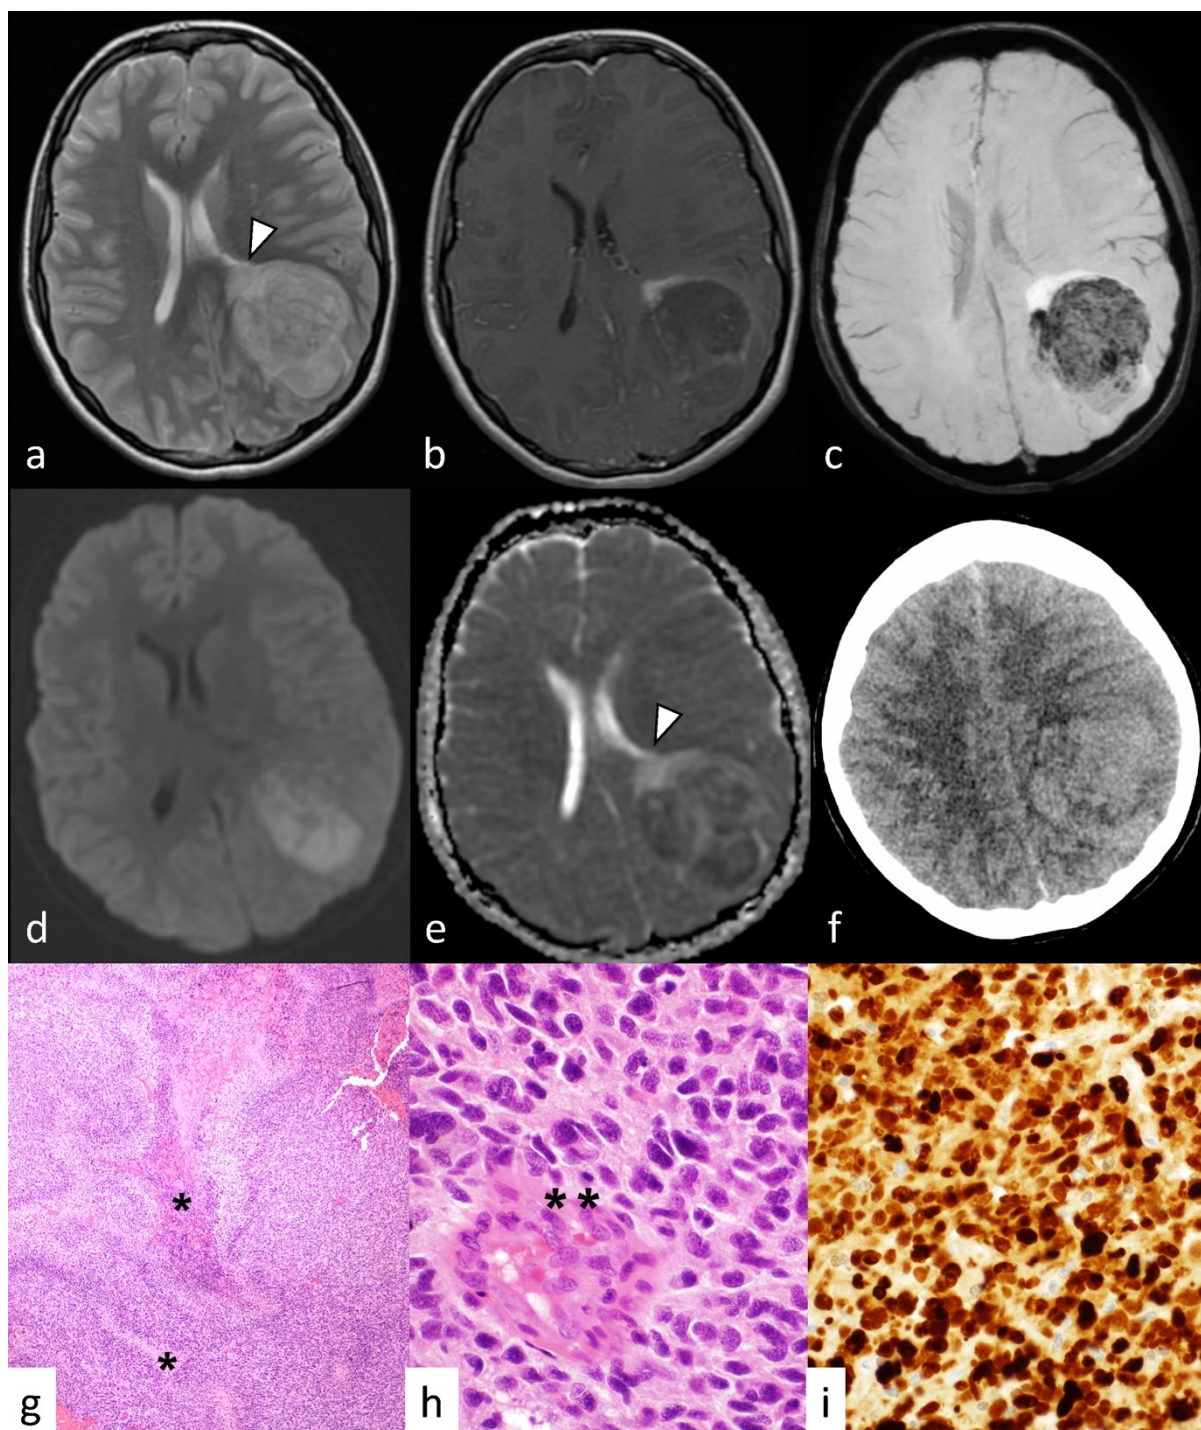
Diffuse hemispheric glioma, H3 G34R-mutant in a 19-year-old female presenting with headache, nausea/vomiting, and blurred vision (case 3). MRI shows a $6.0 \times 5.4 \times 5.1$ cm
